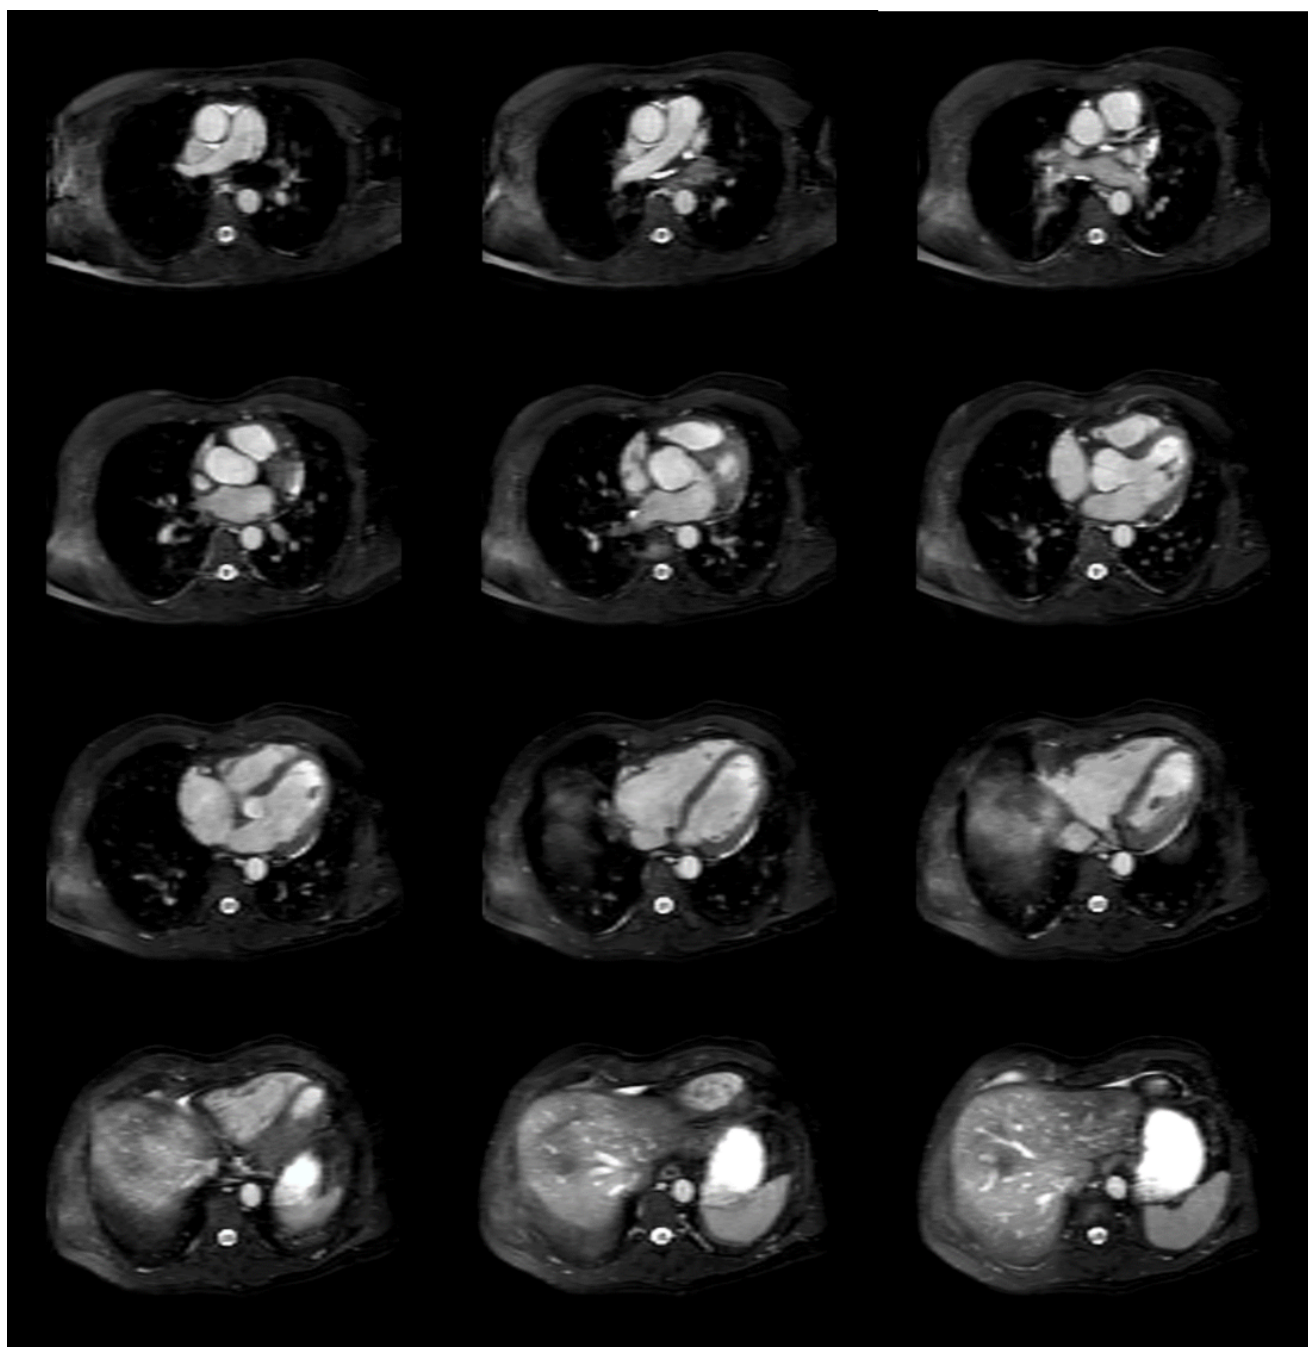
The axial view for the MRI of the second volunteer. Each picture represents one axial layer of the MRI, the distance between the axial layers is 10.5 mm and the original resolution distance is 1.5 mm
